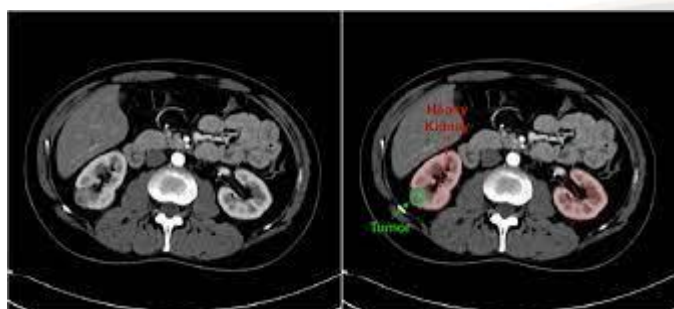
Abnormalities in Kidney CT Scan Images
